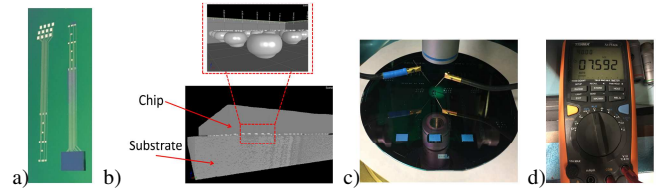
Preliminary results after bonding. CT scans and 2-point measurements have been performed to ensure that the bonding process was successful.
